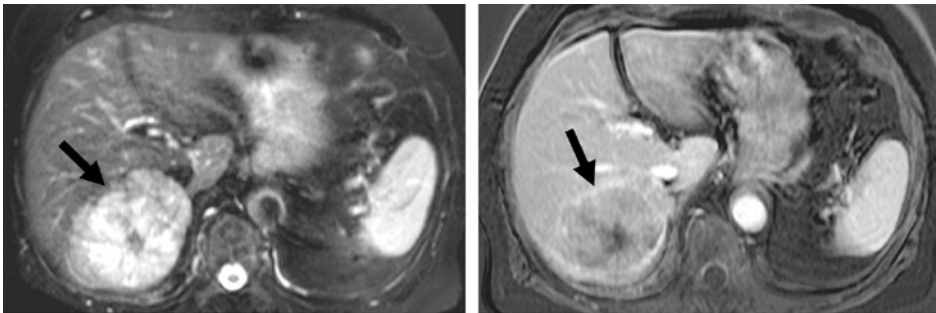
MR imaging appearance of an HCC with a central scar in a patient who was not cirrhotic but who had extremely high levels of α -fetoprotein. a. Axial fat-saturated T2-weighted fast SE image shows a predominantly high-signal-intensity lesion (arrow) with a low-signal-intensity central scar. b. Axial gadolinium-enhanced fat-saturated 2D T1-weighted GRE image obtained during the delayed phase shows washout of contrast material in most of the lesion and an enhanced tumor capsule (arrow). The central scar remains mainly unenhanced.
